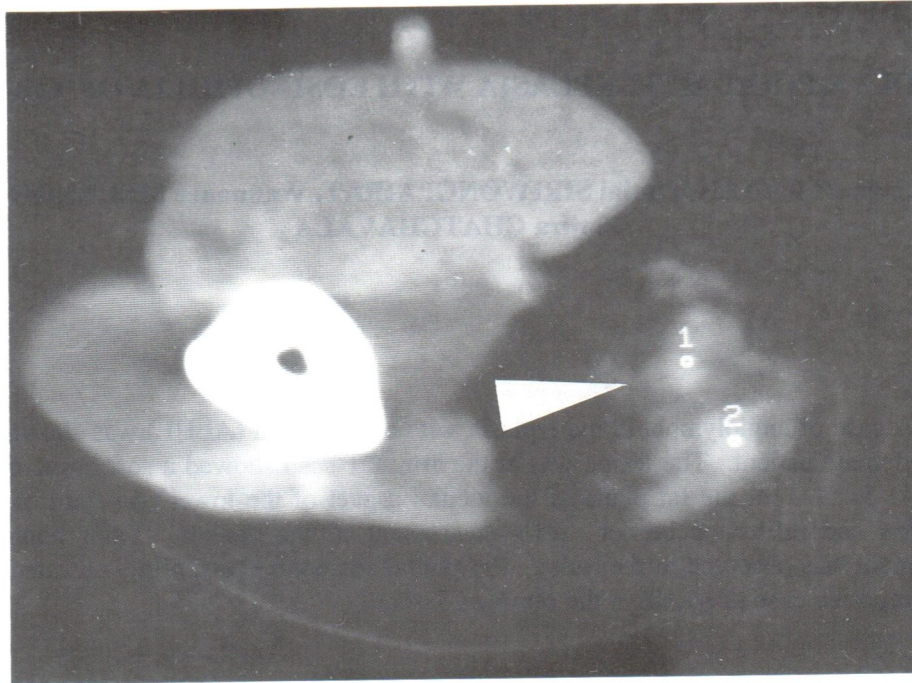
Non enhanced axial CT scan of the right arm showed an infiltrative border solid mass in the subcutaneous fat plane.
